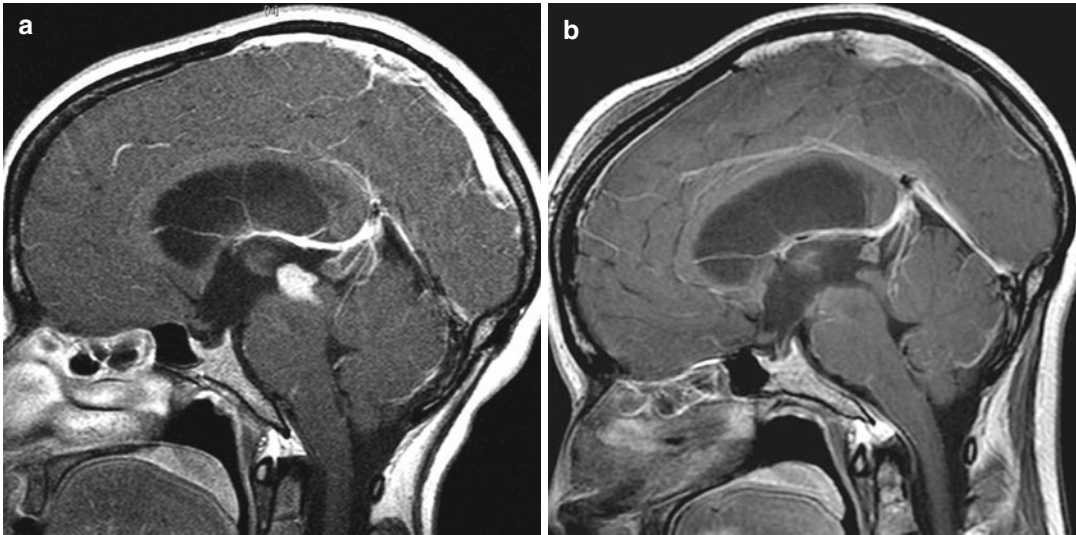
Sagittal MRI with contrast administration prior (a) and after (b) endoscopic total removal of a posterior third ventricular ependymoma
